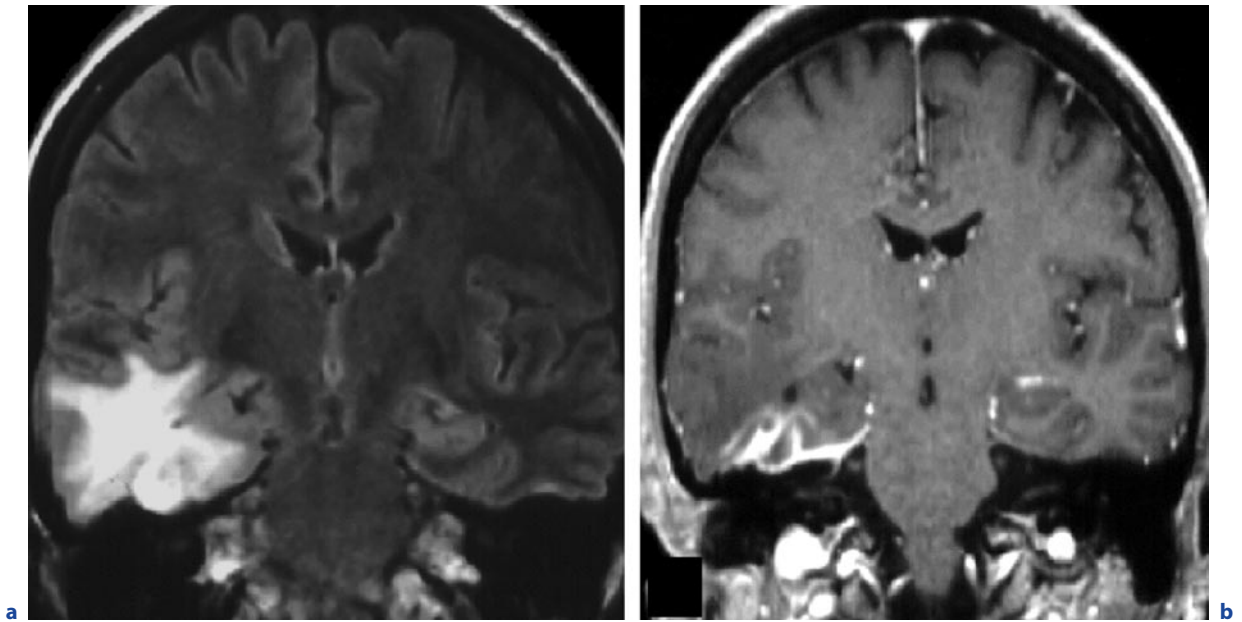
Right temporal cerebritis by local spread of an infection of the adjacent mastoid cells. a Coronal FLAIR image. b Coronal T1-weighted image after contrast administration.
